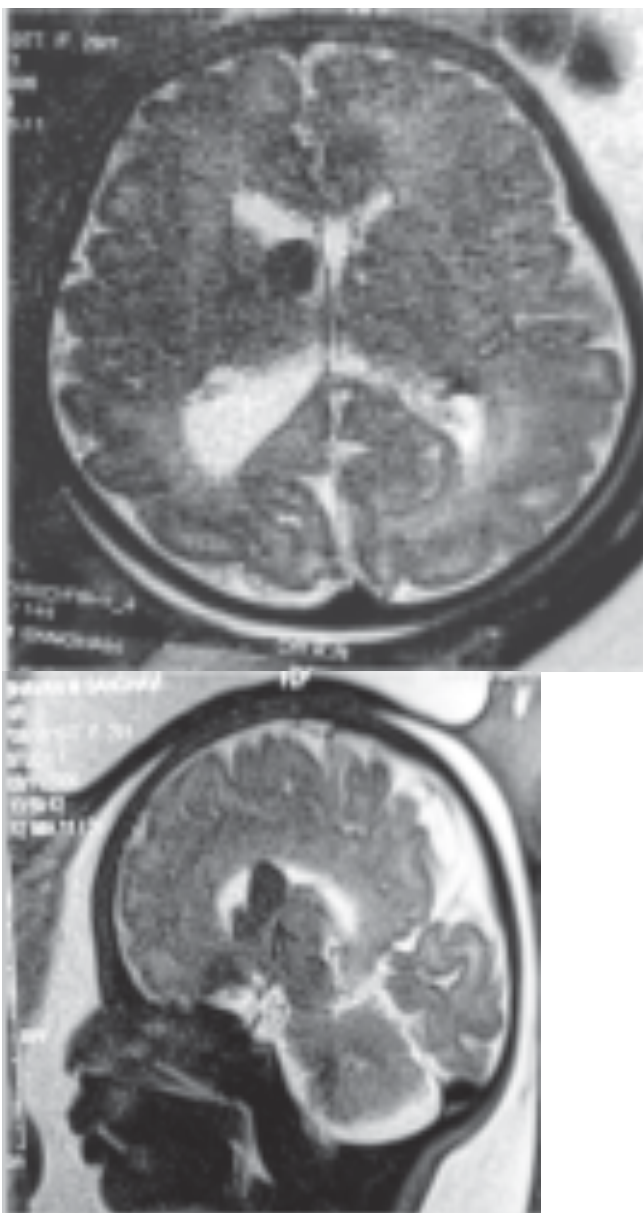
MRI fetal brain showing subependymal nodules
